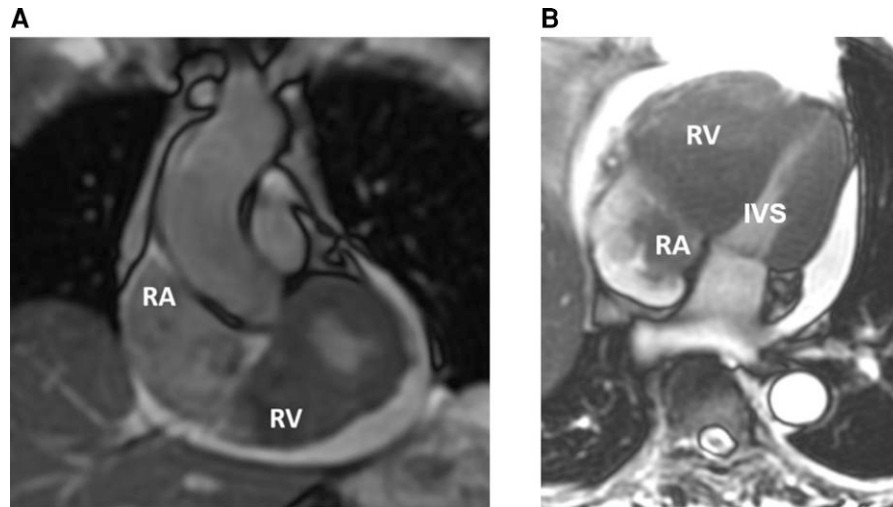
Cardiac magnetic resonance imaging images showing mass obliterating the right ventricular cavity and extending into the right atrium. (A) Sagittal magnetic resonance imaging image of the right ventricular mass with extension into the right atrium. (B) Coronal magnetic resonance imaging image of the right ventricular mass with extension into the right atrium and interventricular septum.
